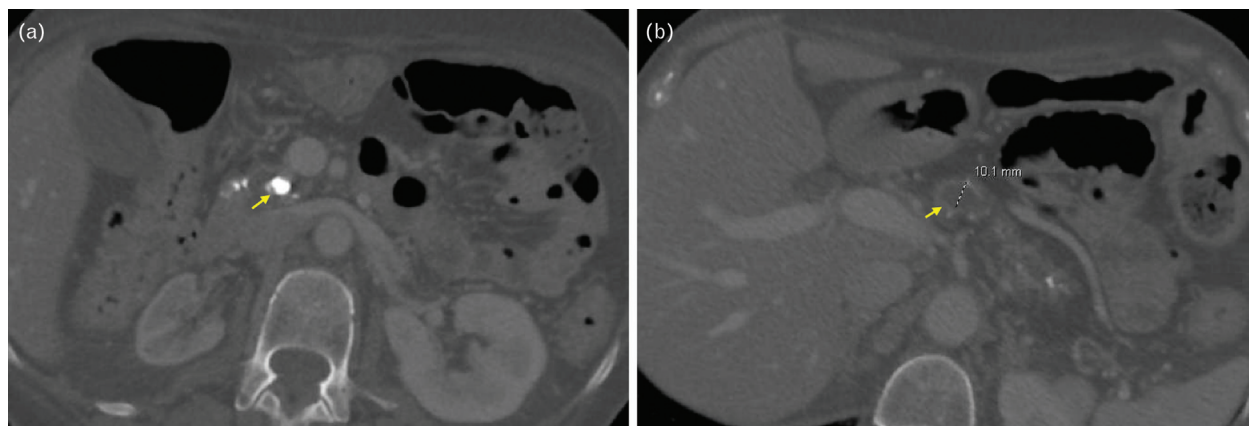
Computed tomographic images depicting: (a) A radio-dense PDC in the pancreatic head, and (b) Upstream pancreatic duct dilation.
